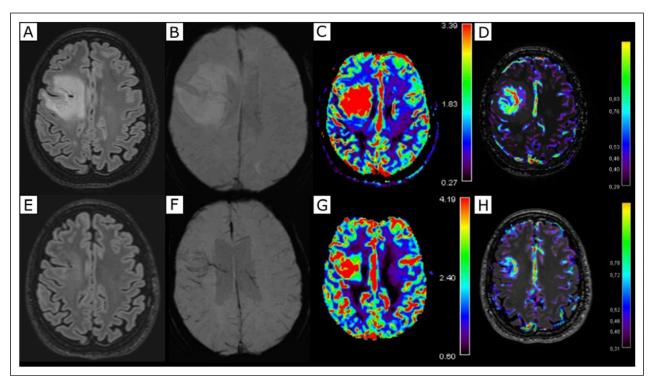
Top row: acute magnetic resonance examination. Bottom row: 3 months follow-up examination. (A and E) FLAIR ponderated sequence, showing the regression of oedema between the acute (A) and follow-up (E) examinations. (B and F) SWI MIP sequence, showing the relative increase in hyposignal the DVA venular network and main collector between acute (B) and follow-up (F) exams. (C and G) rCBV maps, showing a relative decrease of regional blood volume in the DVA between acute and follow-up exam. (D and H) tMIP maps, showing relative decrease in the slowness of the regional blood drainage in the DVA area between acute and follow-up exams.
